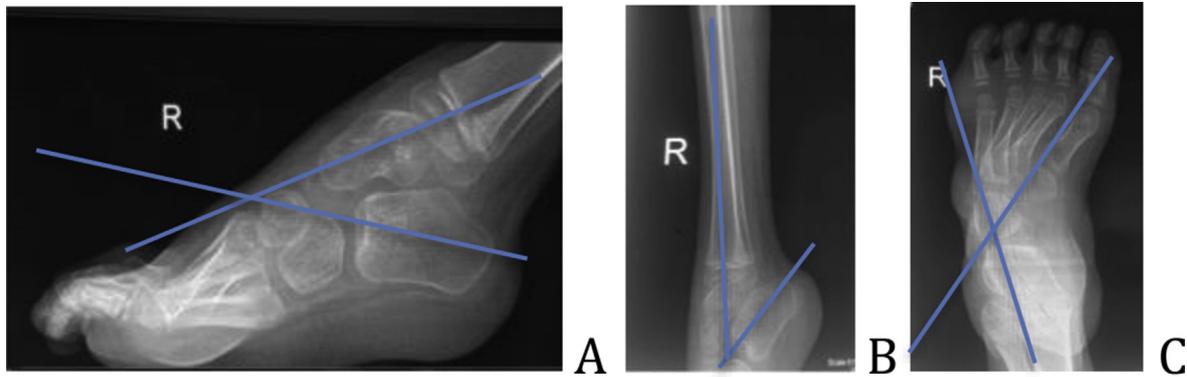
Radiograph of foot and leg showing the angle measurements for assessment. Talo - Calcaneal angle (A)- longitudinal axis of talus and calcaneum bone in lateral view. Tibio Calcaneal angle (B)- longitudinal axis of tibia and calcaneum bone in lateral view. Talo - 1st Metatarsal angle (C)- longitudinal axis of talus and first meta-tarsal bone in AP view.
